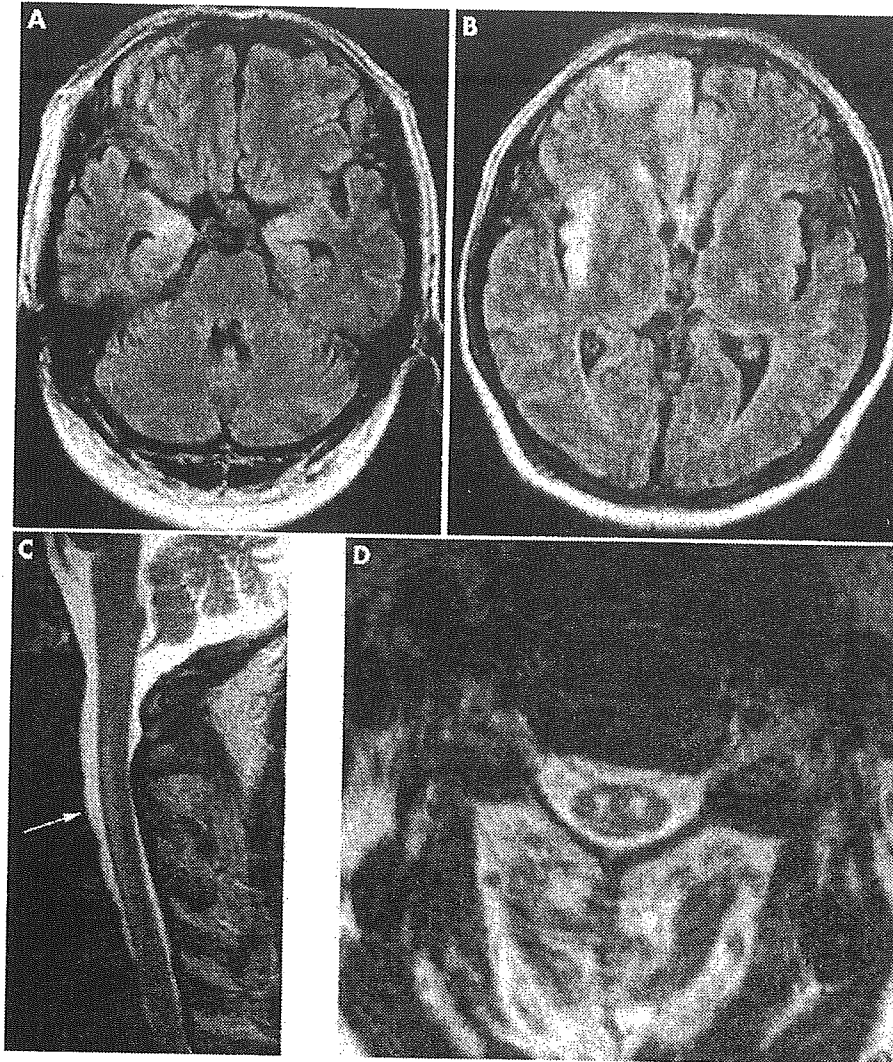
(A, B) The magnetic resonance imaging (MRI) fluid attenuated inversion recovery image on admission demonstrated a high signal intensity in the bilateral mesial temporal lobe, right frontal cortex, and right insula. There was no enhancement by gadolinium-DTPA (diethylene triamine pentaacetic acid). These abnormal signal lesions disappeared following treatment with intravenous immunoglobulin and steroids. (C, D) T2 weighted MRI demonstrated a symmetrical high signal lesion (arrow), which was relatively confined to the grey matter of the cervical spinal cord. The lesion was not enhanced by gadolinium-DTPA.
